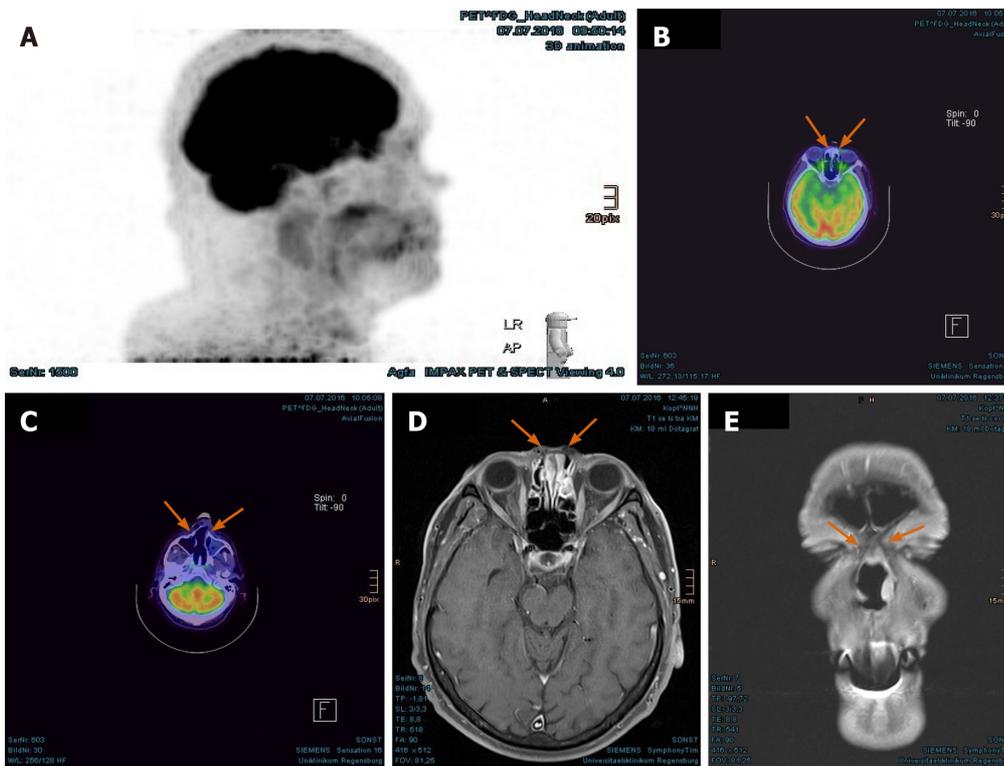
Persisting tumor remission evidenced in the positron emission tomography with 2-deoxy-2-fluorine-18-fluoro-D-glucose/computed tomography and magnetic resonance imaging at 20 mo after proton beam therapy. A: No pathologically increased activity in the positron emission tomography, overview image; B: Absence of increased fluoro-D-glucose avidity in the nasal bridge (arrow-marked in positron emission tomography/computed tomography); C: Absence of metabolically active tumor in the nostrils; D: Flat surface above the nasal bridge in the magnetic resonance imaging; E: No evidence of tumor enhancement in the nasal bridge, presented in coronal plane.
